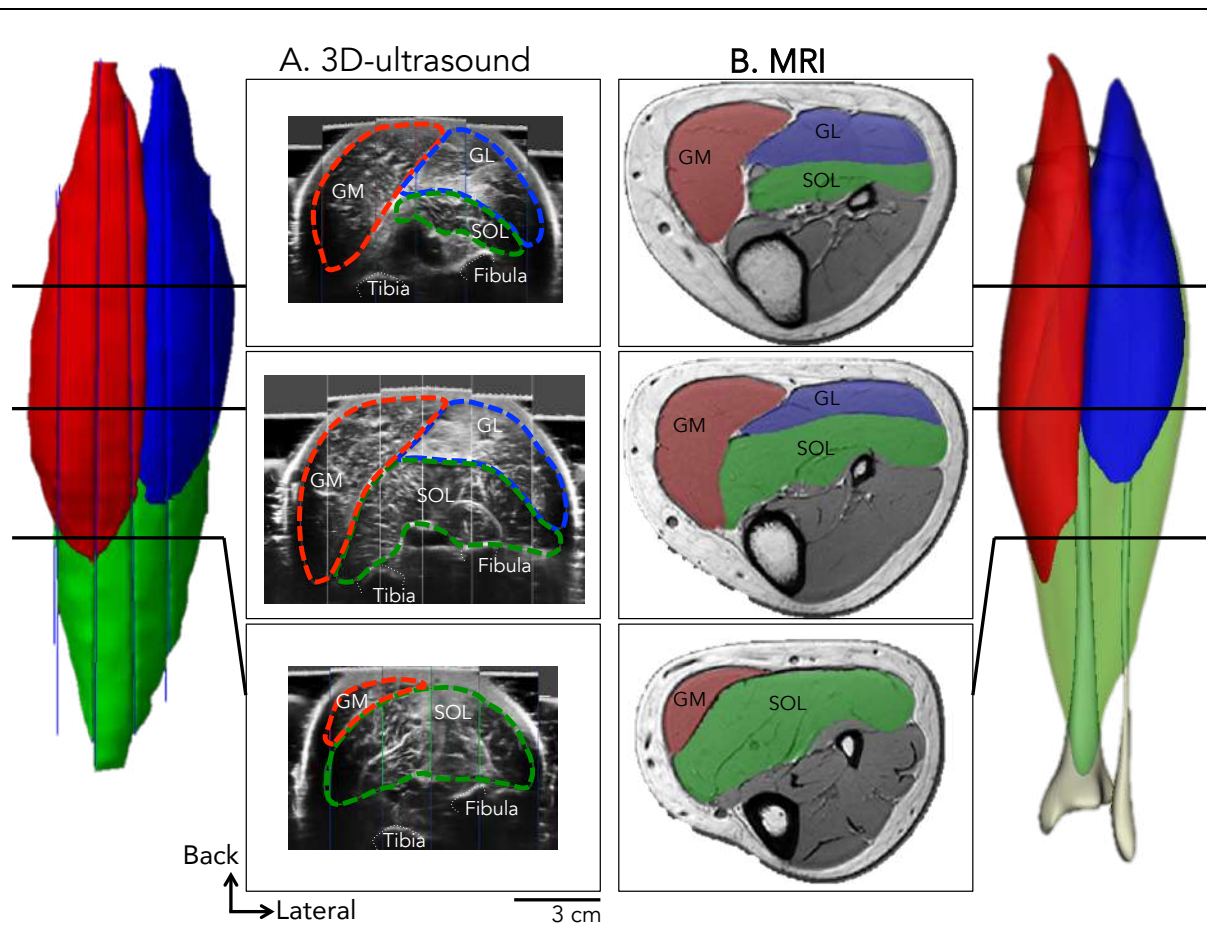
Triceps surae* volume collected with 3D ultrasound (panel A) and MRI (panel B) on two different participants. Volume reconstruction of each technique is drawn on the lateral sides. Cross-sectional areas have been extracted at approximately 25, 50 and 75 % of leg length. Note the different aspect of the leg shape: participants were lying front (panel A) and supine (panel B). Cross-sectional areas in panel B have been flipped vertically in order to align views between the two techniques. GM, gastrocnemius medialis; GL, gastrocnemius lateralis; SOL, soleus.
